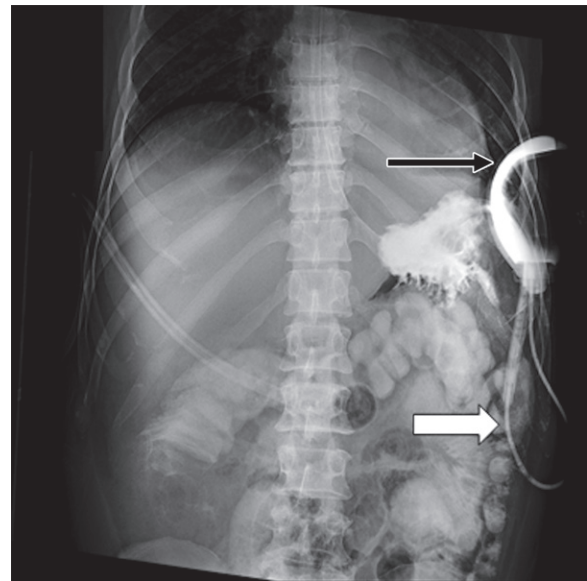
Supine anterior-posterior portable abdominal radiograph obtained 1 hour after a water-soluble single-contrast UGI in a 49-year-old man after gastric perforation repair. Enteric contrast agent is demonstrated within the surgical drain tubing (white arrow) and bulb (black arrow), indicating a leak.
